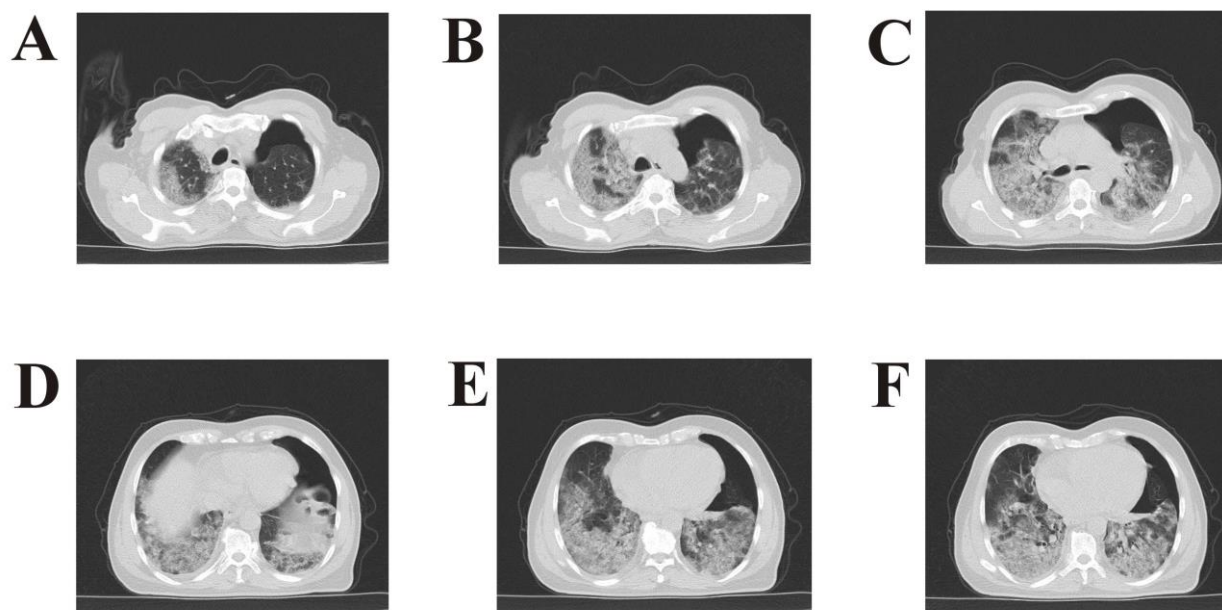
Chest computed tomography scan of the patient; presence of bilateral pulmonary involvement, more prominent in the lower fields of both lungs (D-F) and upper fields of the right lung (A-C)
